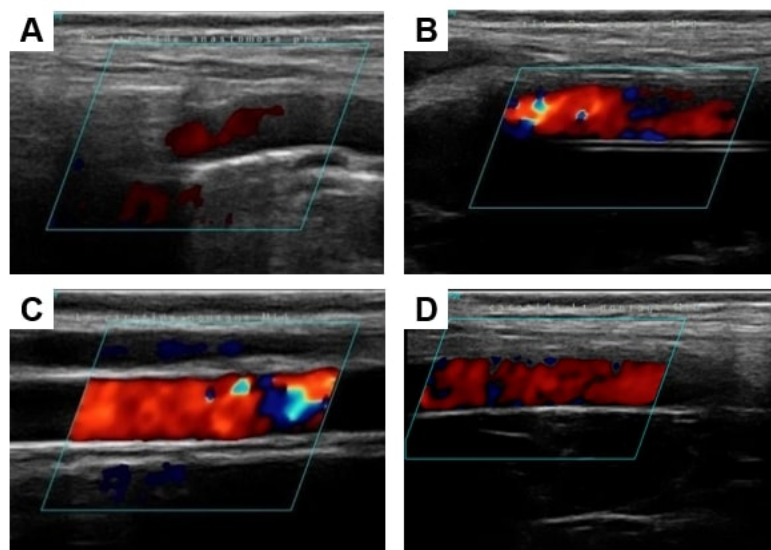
Doppler ultrasound images for ePTFE (A, B) and eVG-CS (C, D) grafts post-operatively (A, C) and 1 week after the implantation (B, D). All images taken at mid graft, except for (A) taken at proximal anastomosis because of the absence of Doppler signal inside the ePTFE prosthesis just after implantation.
